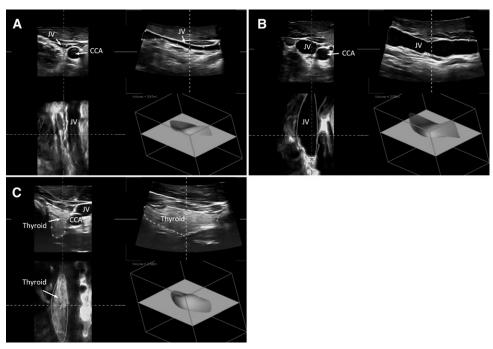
Images of the 3D ultrasound assessments of JV volume A) PRE and B) after 2 h of DI, and C) thyroid volume after 2 h of DI. The 3D reconstructions (bottom right in each image) were computed using 2D images in the transverse (top left), sagittal (top right), and frontal (bottom left) planes.
